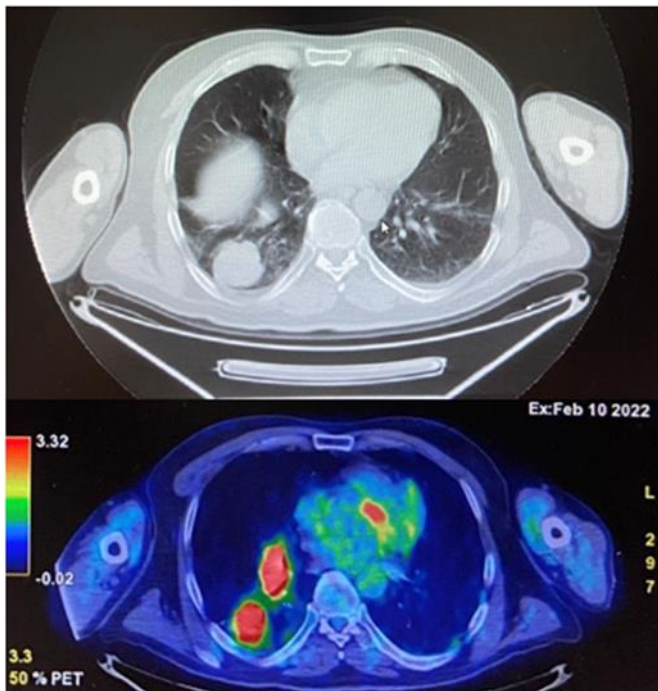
A) total body Computed Tomography (CT) -scan frame showing between the lateral and posterobasal segment of the right lower lobe the expansive lesion with inhomogeneous density (4x3.8x3.7 cm); B) PET-FDG-scan frame showing pathological uptake between the lateral and posterobasal segment of the right lower lobe.
